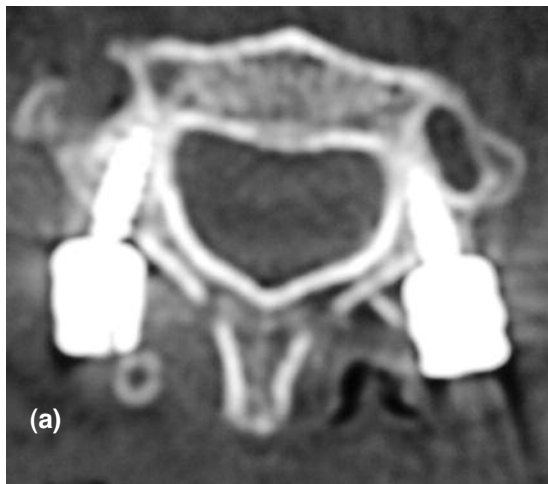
(a-c) Postoperative CT scans demonstrating accurate pedicle screw placement in the pedicles of the different levels.
